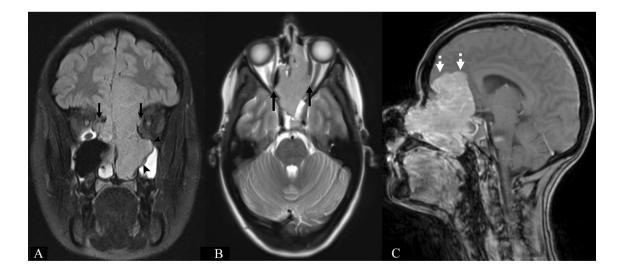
Coronal FLAIR image from the MRI (A) shows a large sinonasal mass that extends into the bilateral extraconal orbit (arrows) as well as into the left maxillary sinus (arrowheads) and anterior cranial fossa. Axial turbo spin echo T2-weighted image (B) shows an intermediate intensity extra-axial mass centered in the sinonasal cavity that extends into the extraconal orbit bilaterally with mass effect on the medial rectus musculature (arrows). Sagittal T1-weighted image with contrast ( $\mathbf{C}$ ) demonstrates the avid enhancement of the mass which also extends into the anterior cranial fossa and exerts mass effect on the frontal lobes and corpus callosum (dashed arrow)
